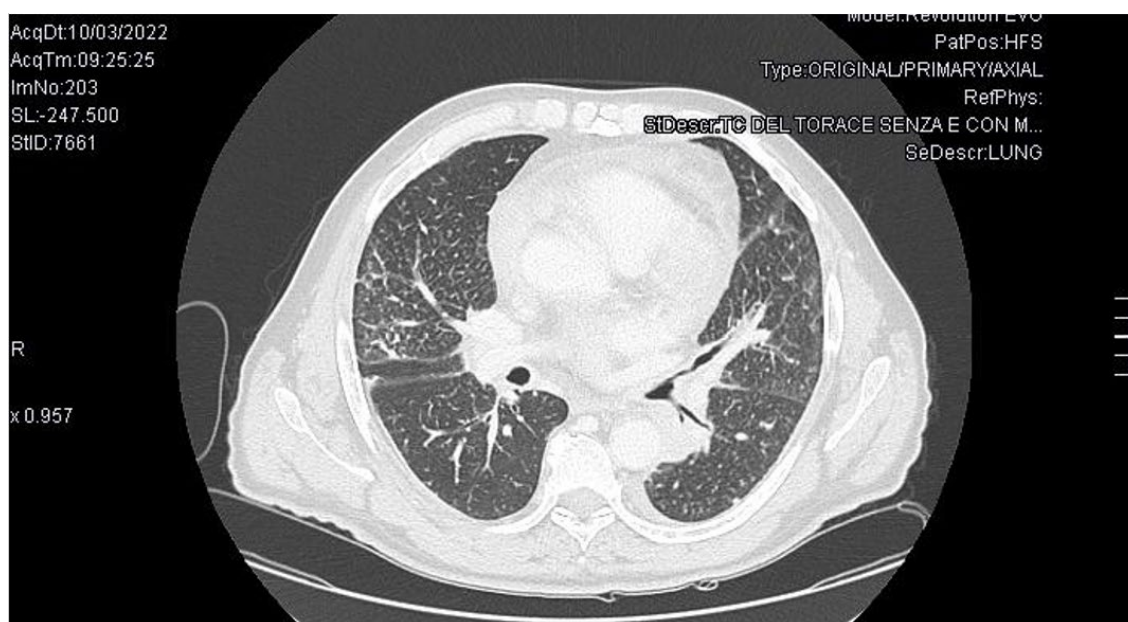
Chest CT scan: a tissue mass in the left hilar para-aortic region causing narrowing of the bronchial structures.
